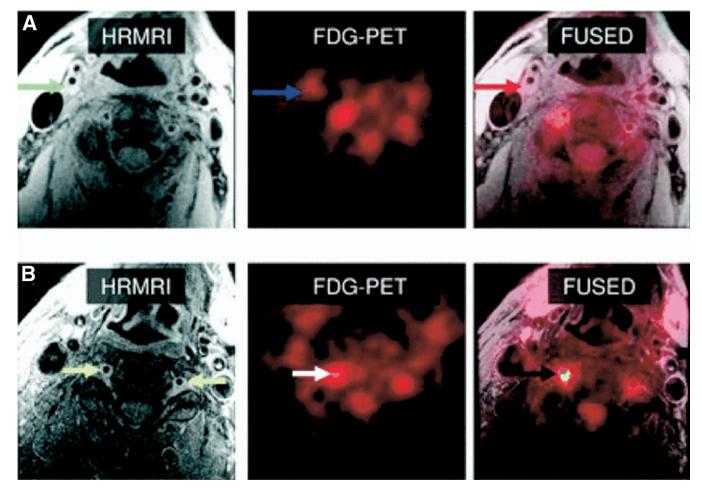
Identification of "vulnerable" carotid plaques. High-resolution MRI and FDG- PET scans in a patient with recent right carotid territory stroke soon after a transient visual disturbance in conjunction with a stenosis of the RICA on conventional angiography are shown. (A) Axial images at a level of the proximal RICA demonstrate RICA plaque targeted for endarterectomy (green arrow). Despite its supposed importance and appropriate location, only low FDG uptake is demonstrated (blue and red arrows). (B) Axial images 3 cm above those in (A). Vertebral arteries (yellow arrows) are well seen. White arrow on FDG-PET image highlights an area of high FDG uptake, which overlies the right vertebral artery on PET/CT image (black arrow). Inflamed vertebral artery plaque may likely be a cause of the patient's symptoms. Active and "vulnerable" plaque may not necessarily be the largest, most stenotic, or even located in the most likely culprit vessel. (Reprinted with permission.¹⁰²)
